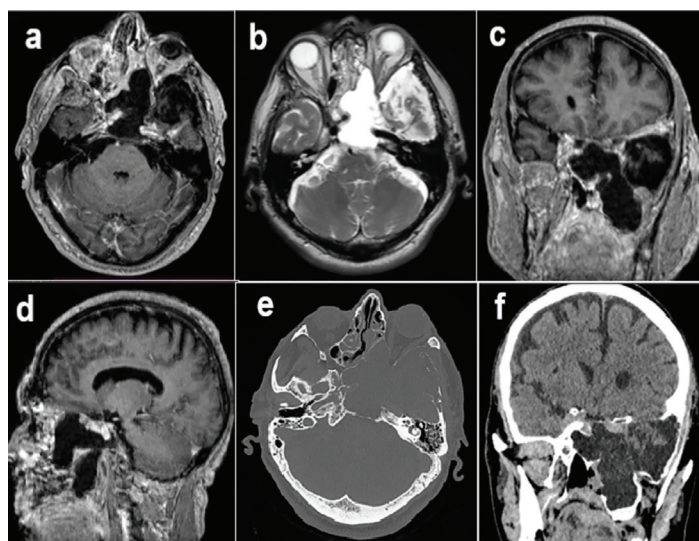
Preoperative axial T1-W (a), axial T2-W (b), coronal T1-W (c), and sagittal T1-W (d) MRI showing a giant cystic mass occupying almost the entire ventral skull base, involving the left cavernous sinus, and also extending into the left middle cranial fossa, and infratemporal fossa. Preoperative axial bone window (e), and coronal (f) CT scans demonstrating significant bone resorption in the ventral skull base including anterior fossa, sella floor, clivus, and sphenoid sinuses as well as bony defects in some areas
